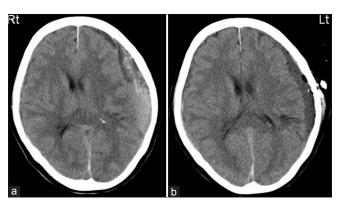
(a) Initial CT scan showing left CSDH and (b) CT scan after irrigation
